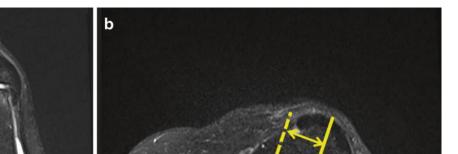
(a, b) MRI demonstrating increased TT-TG distance and patellar malalignment. *Solid line* demonstrates trochlear groove in a and tibial tubercle in b. *Dashed lines* indicate the superimposed line of the opposing structure. The *arrow* represents the TT-TG distance
